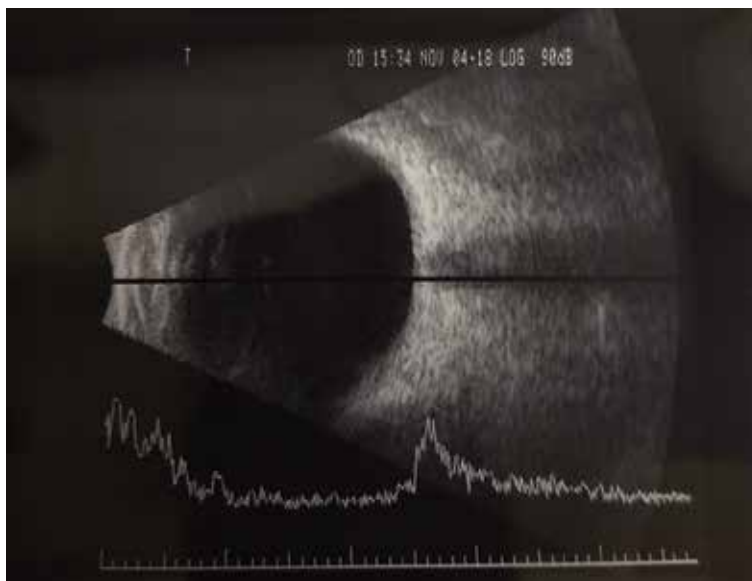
The 2D image is an example of B-scan ultrasonography of a human eye. The lower section of the image shows a superimposed A-scan for comparison.
